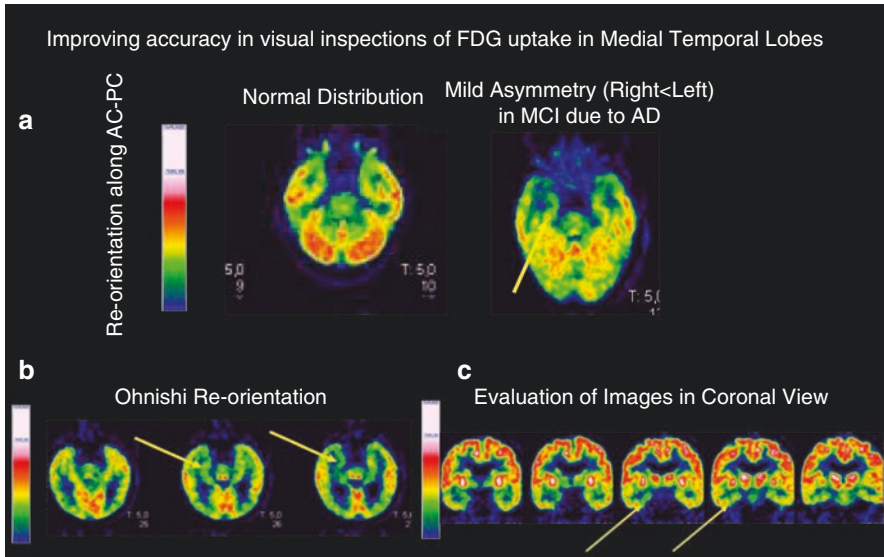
Evaluation of medial temporal lobe (MTL) on FDG-PET. Panel a: FDG-PET images of a healthy control (normal scan, left side) and of an AD patient (right side: mild asymmetry in MTL with right < left). Both scans are reoriented along the anterior-commissural/posterior-commissural line (AC-PC). Panels b and c show the FDG-PET images of the same AD patient visualized according to Ohnishi reorientation and in coronal view, respectively. The asymmetry between right and left MTL (yellow arrows) is more evident both in Panels b and c than in Panel a. See the main text for further details
